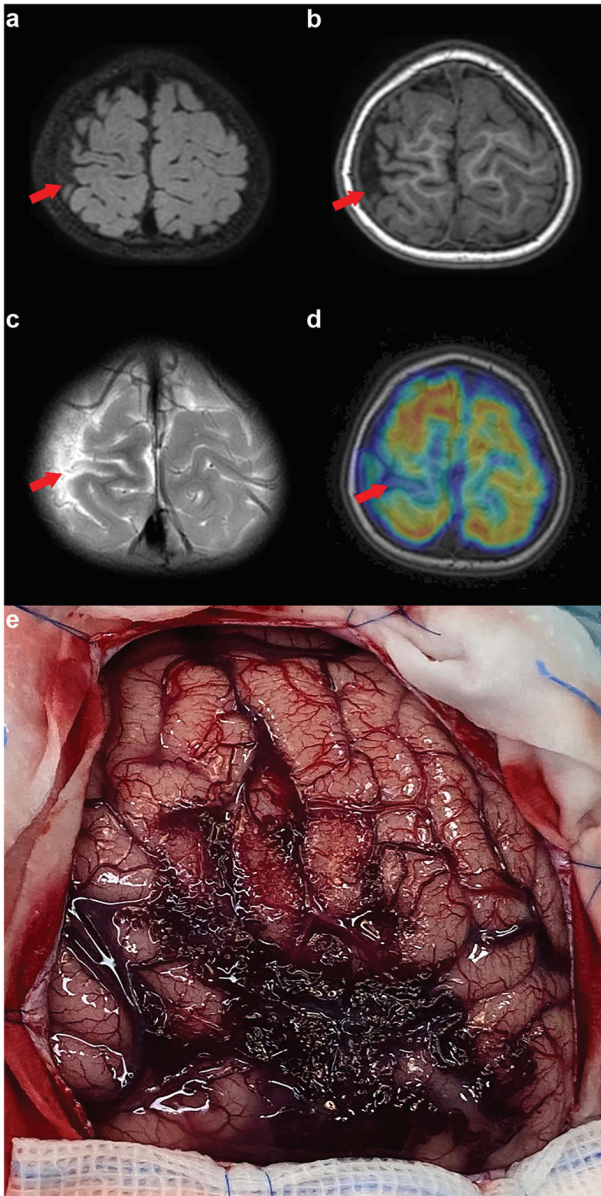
Brain magnetic resonance imaging and intraoperative image detailing abnormalities in the right parietal lobe. (a) Diminished size of the right parietal gyrus with evidence of local cortical dysplasia. (b) Enhanced vascular shadows suggesting multiple disorders in the right parietal space, pointing to vascular malformations. (c) Positron emission tomography-computed tomography scan revealing a low metabolic signal in the right posterior central gyrus. (d) Intraoperative visual field capturing a vascular mass in the right parietal area. (e) Vascular malformation in the right parietal region shows a complex network of enlarged and intertwined vessels that appear redder or sometimes deep blue, reflecting the oxygenation status within these abnormal vessels. The irregular shape of the vascular malformation is evident, with intricate paths through brain tissue clearly discernible. Surrounding the malformation, there may be signs of tissue atrophy or damage. The red arrow indicates the lesion.
